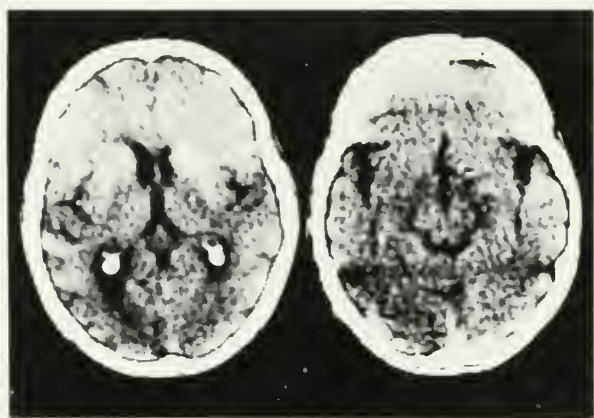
X-ray computed tomographic scan performed two years after onset of illness demonstrates mild atrophy of the left temporal lobe and significant dilatation of the left lateral ventricle.
